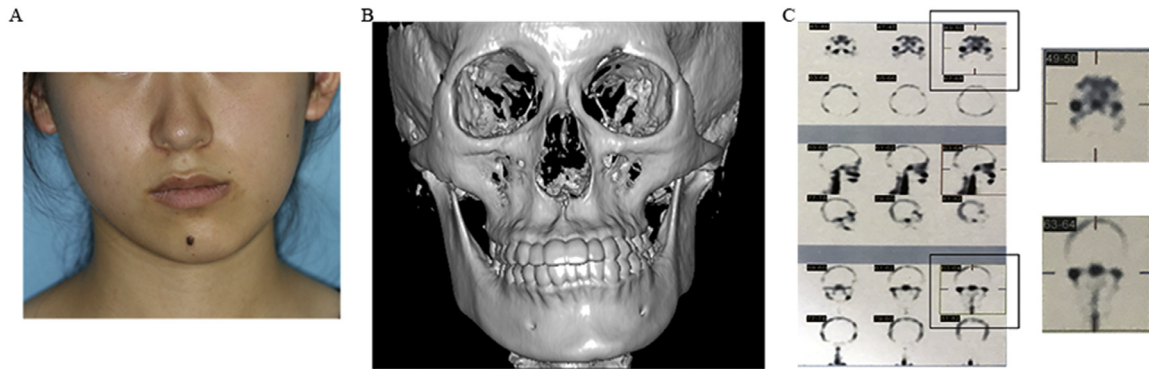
The clinical features and radiologic observations of one representative patient with condylar hyperplasia (CH). A, A frontal view of the patient. B, A 3-dimensional reconstruction image of the maxillofacial region. C, A single-photon emission computed tomography (SPECT) scan showing that the bone activity in the affected condyle (*right side*) was strongly enhanced.
